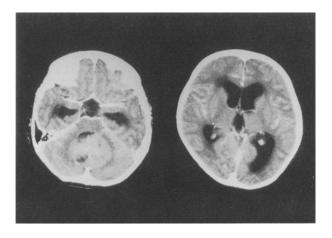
Preoperative enhanced CT shows a lesion located at the cerebellar vermis with a cystic component and uniform enhancement and acute hydrocephalus.
